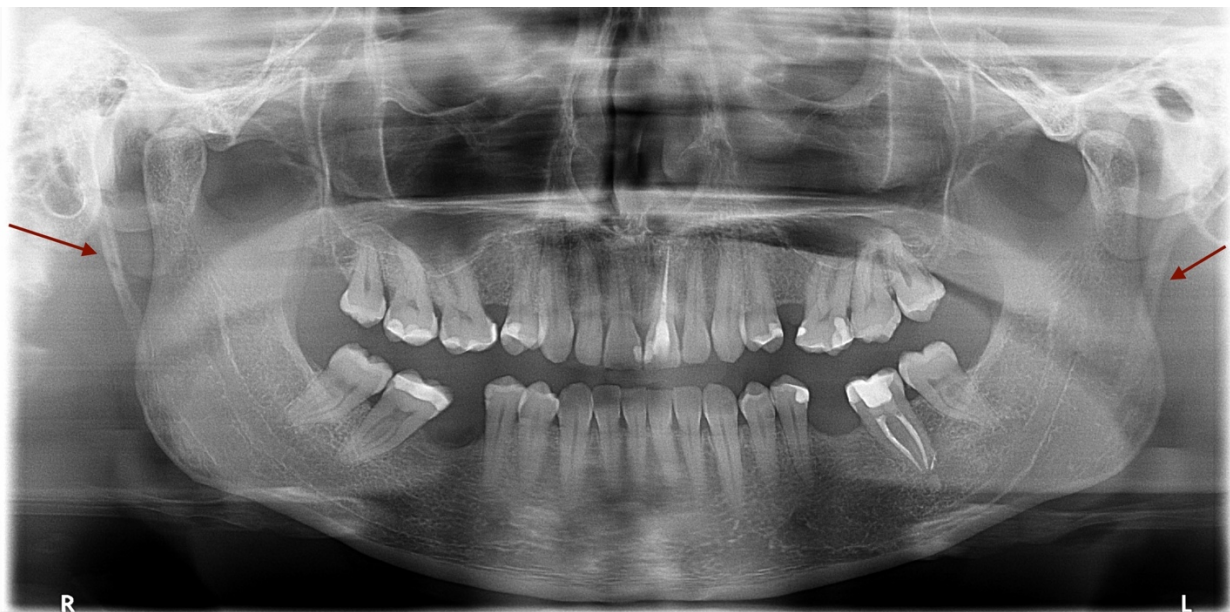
Orthopantomography revealing bilateral elongated styloid processes (*red arrows*).
